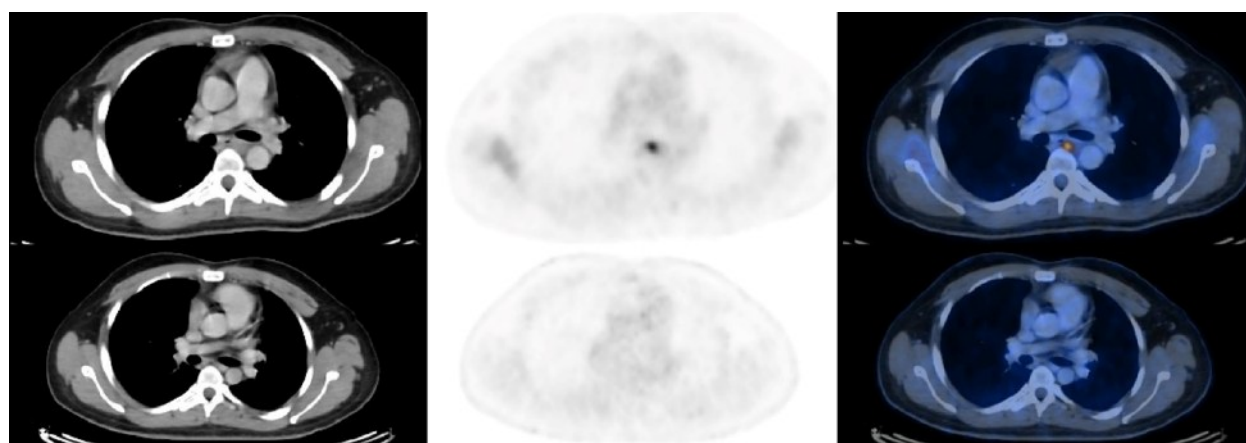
Axial view showing the (A) CT, (B) PET, and (C) fused PET/CT images of the patient's second whole-body PET/CT scan showing resolution of the mediastinal lymph nodes. Initial PET/CT scan (1st row) and follow-up PET/CT scan (2nd row).
